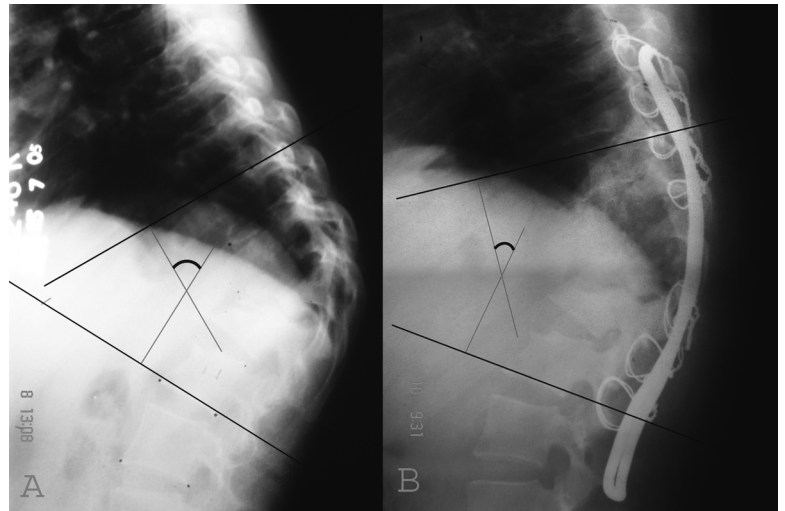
(A) Preoperative and (B) postoperative radiographs of an adult patient show a kyphus angle (K) of 66° at the dorsolumbar spine, which has been corrected to 32° .
